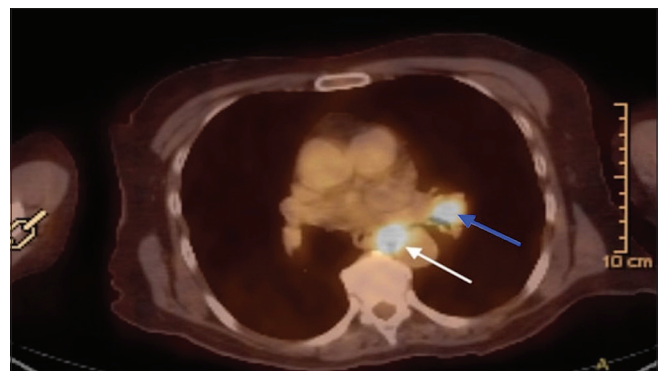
Positron emission tomography – computed tomography images showing an ill-defined left hilar lymph node (station 11 L, dotted blue arrow) measuring approximately 1.2 cm × 1.0 cm with a standardized uptake value of 11.5, and a subcarinal lymph node (white arrow) measuring 1.4 cm × 1.5 cm with a maximum standardized uptake value of 13.4
